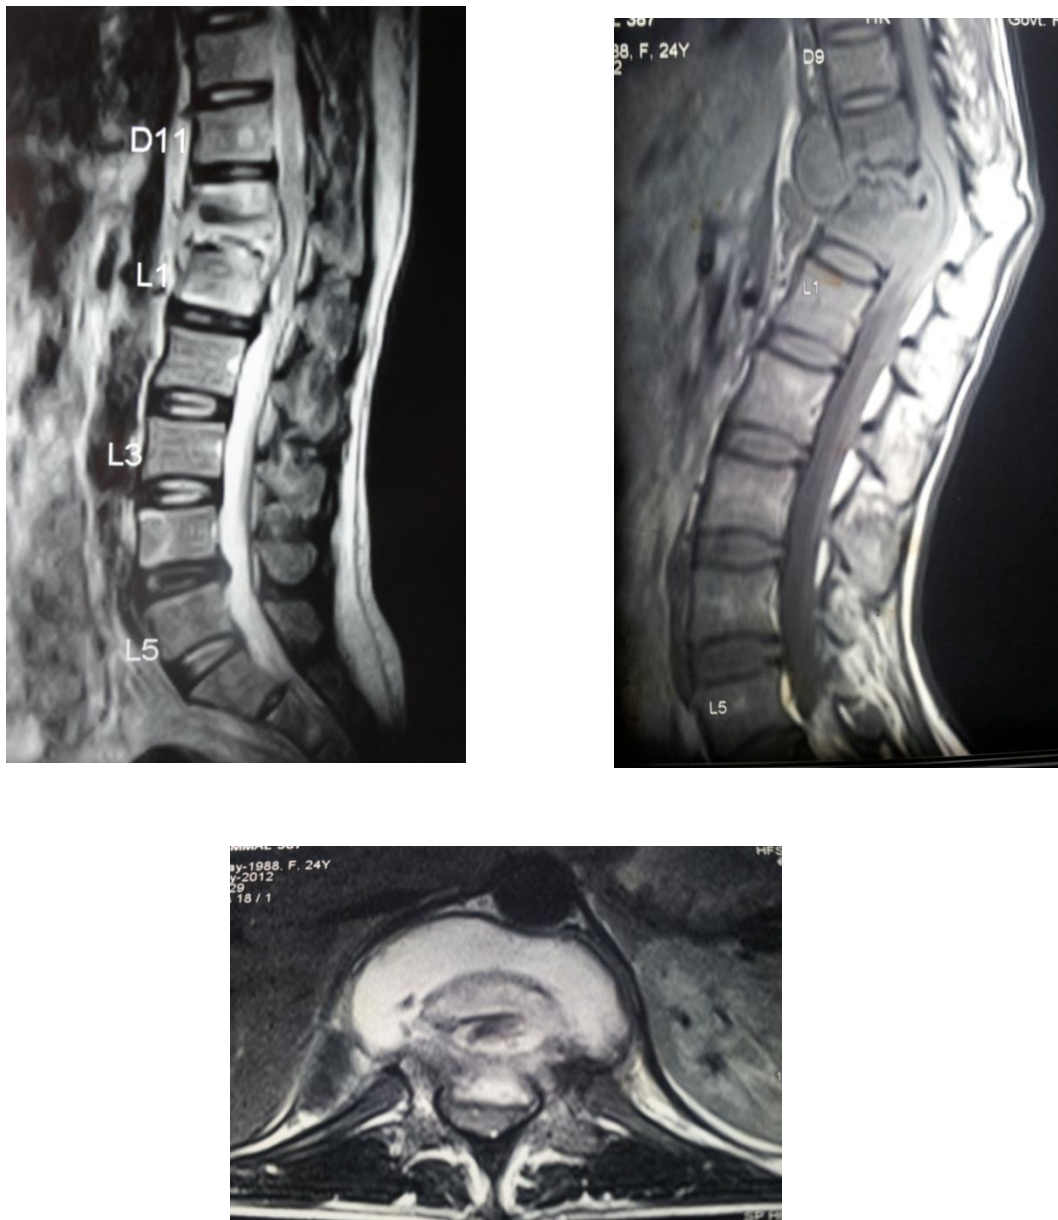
MRI of D12-L1 Tuberculosis of spine
